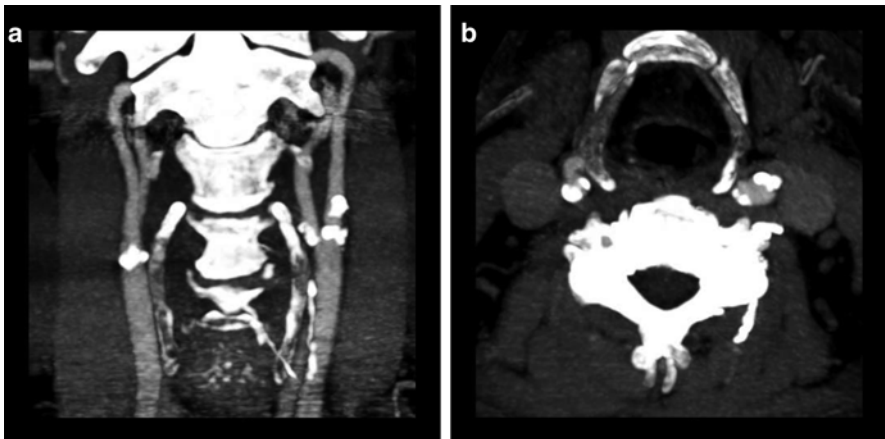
88-year-old male presenting with transient ischemic attack. (a) A coronal CTA MIP image displays moderate predominantly calcified atherosclerotic disease of the bilateral carotid bifurcations. The MIP technique allows the higher density calcified atherosclerotic plaques to obscure the vessel lumen. (b) An axial CTA MIP image through the level of the carotid bifurcations more accurately displays the mild left and moderate right stenosis at the level of the internal carotid artery origins
